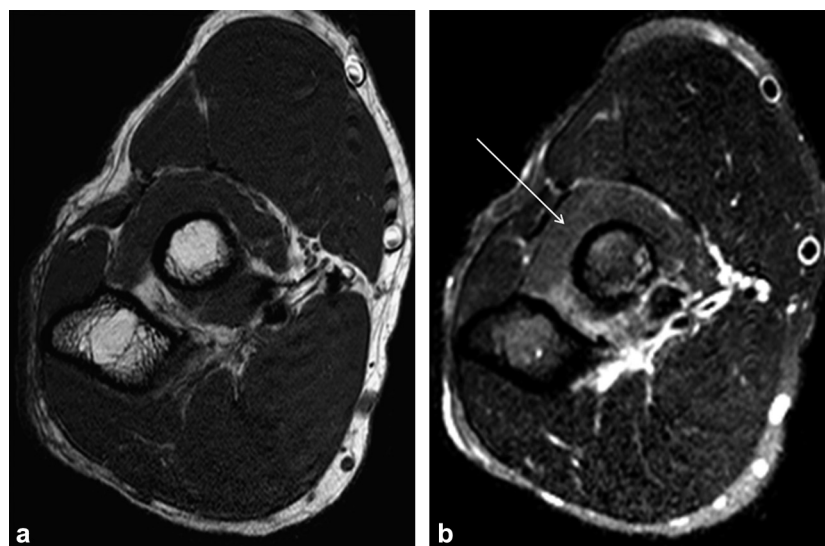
MR imaging shows signs of denervation of the supinator muscle in a patient with atypical lateral epicondylar pain suggestive of radial tunnel syndrome. a: T1-weighted MR image in the transverse plane shows no abnormal muscle degeneration; b: T2-weighted STIR image in the transverse plane shows increased signal intensity in the supinator muscle (arrow).
